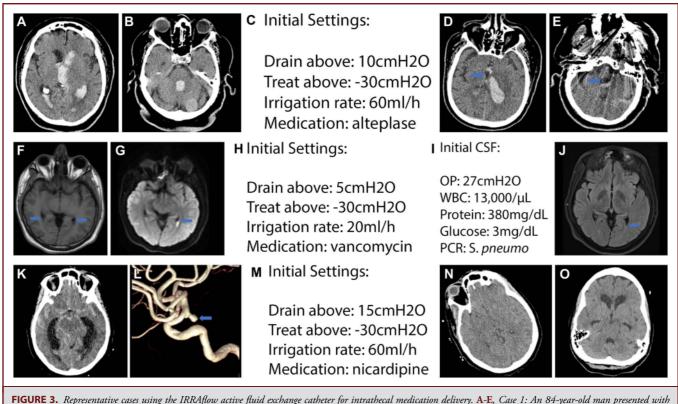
Representative cases using the IRRAflow active fluid exchange catheter for intrathecal medication delivery. A-E, Case 1: An 84-year-old man presented with hypertensive thalamic hemorrhage and occlusion of the third and fourth ventricle with obstructive hydrocephalus. IRRAflow was placed at bedside hospital day 0, and alteplase infusion started after postprocedural scan showed no hemorrhage or progression of disease. The patient improved neurologically, but family elected for withdrawal of lifesustaining care rather than tracheostomy placement. A and B, Axial CT scans demonstrating IVH with the occlusion of third and fourth ventricle. C, Initial settings of the IRRAflow catheter. D and E, Axial scans from postbleed day 2 showing patency of third and fourth ventricle and decreased blood clot burden. Blue arrows represent patients' third and fourth ventricles with decreased blood clot burden. F-J, Case 2: A 21-year-old man with spontaneous bacterial ventriculitis related to sinus infection, treated at community hospital with antibiotics with no improvement for 3 days and transferred to university hospital after becoming comatose. After a 9-day treatment course in the neuro-intensive care unit, the patient improved substantially, was extubated, and transferred to the general floor. The patient recovered completely and now living independently. F, T1 noncontrasted axial MRI of the brain showing purulent ventriculitis. Blue arrows represent fluid-fluid level in occipital horns. G, Diffusion-weighted axial MRI of the brain showing restricted diffusion in fluid of occipital horn. Blue arrows represent restricted diffusion in dependent fluid. H, Initial settings of the IRRAflow catheter. I, Initial cerebral spinal fluid laboratory analysis. J, T2 fluid-attenuated inversion-recovery axial MRI taken on hospital day 13 showing resolution of intraventricular purulence and no cerebral edema. Blue arrows represent lack of fluid-fluid level in occipital horn. K-O, Case 3: A 48-year-old woman presented to community hospital with worst headache of life. Deteriorated to stupor. Hunt-Hess grade 5, Fisher grade 4 subarachnoid hemorrhage diagnosed. The patient transferred emergently to university hospital. IRRAflow was used to deliver nicardipine prophylactically from posthemorrhage days 3 to 10. After a prolonged hospital stay including 2 intra-arterial treatments for vasospasm as well as a tracheostomy, the patient made an excellent recovery and was discharged home. At 4 months posthemorrhage, she was neurologically intact and living independently. K, Noncontrast axial CT of the brain showing diffuse subarachnoid hemorrhage and hydrocephalus. L, 3-dimensional reconstruction from digital subtraction angiography showing the cerebral aneurysm. M, Initial settings of the IRRAflow catheter. N, Noncontrast axial CT of the brain from postbleed day 5 showing cerebral edema but resolved hydrocephalus and resolved subarachnoid hemorrhage. O, Noncontrast axial CT of the brain 4 months after hemorrhage showing ventriculomegaly without sulcal effacement and resolved cerebral edema. CT, computed tomography; CSF, cerebral spinal fluid.
